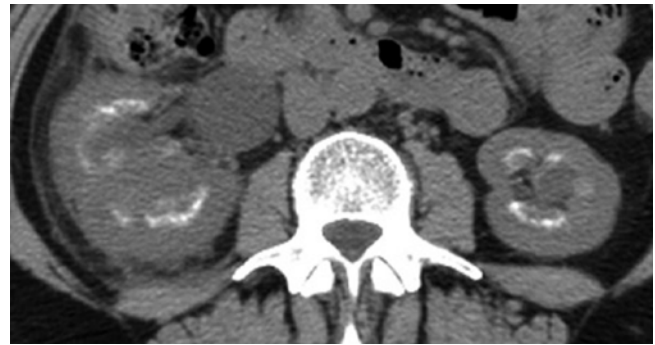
Unenhanced CT demonstrating extensive parenchymal calcification in a patient with medullary sponge kidney with perinephric stranding and an enlarged kidney
